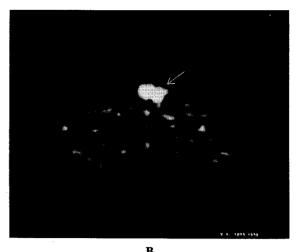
(A) FDG-PET transaxial sections of a 53-year-old male with the normal testes, sequentially from the lower pelvis to the inguinal region. Intense, focal FDG uptakes of two contiguous foci are noted between the legs in the lower two rows (arrow). There is urinary FDG in the bladder and penis, and mild FDG accumulation is noted in the rectum. (B) Magnified transverse FDG-PET image of the same patient. Note intense uptakes of FDG in the normal testes.
